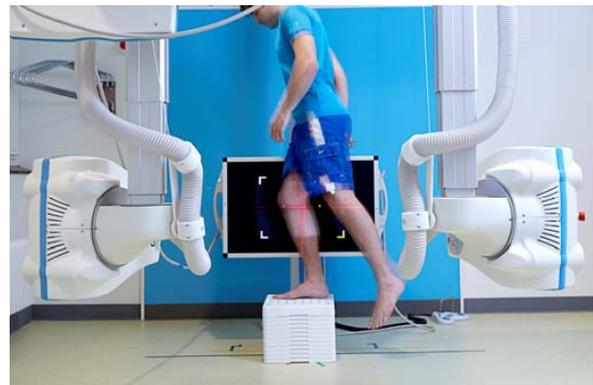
Dynamic RSA set-up for assessment of the knee during a step-up motion (AdoraRSA, Nordic X-ray Technique, Denmark).
